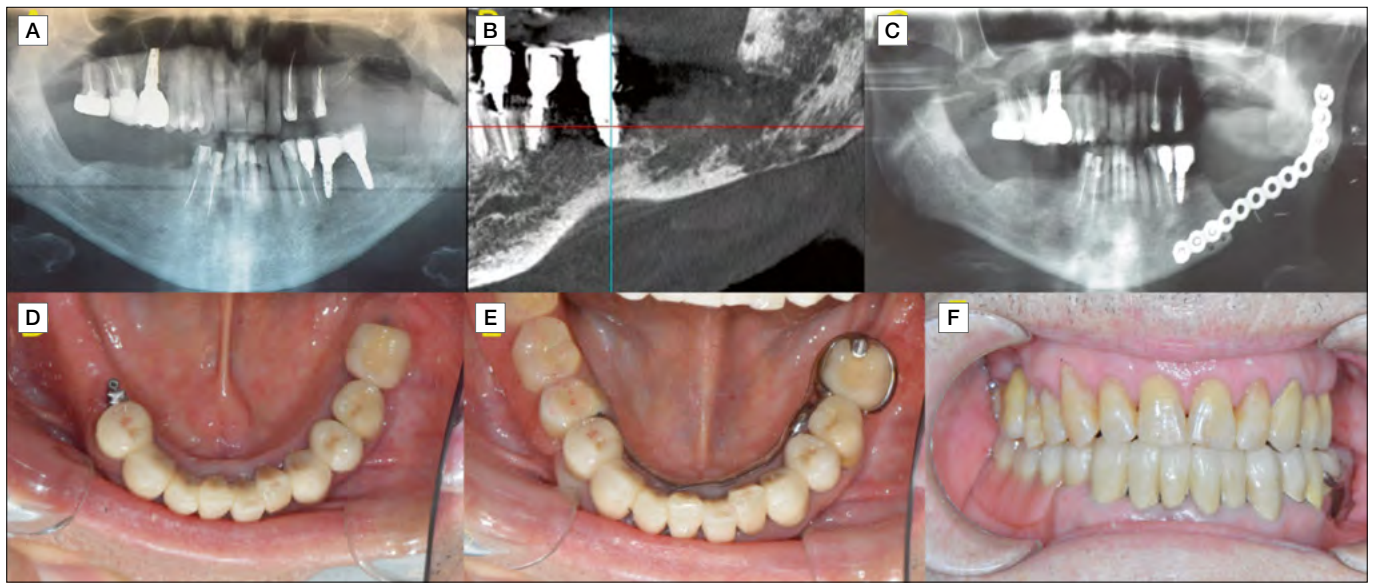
ORN of the left jaw (A); dental implant involvement in the ORN (B); orthopantomography after 3 months from surgery (left mandibulectomy, reconstructive plate with pectoralis major flap (C); conventional prosthetic dental rehabilitation (D-F).
